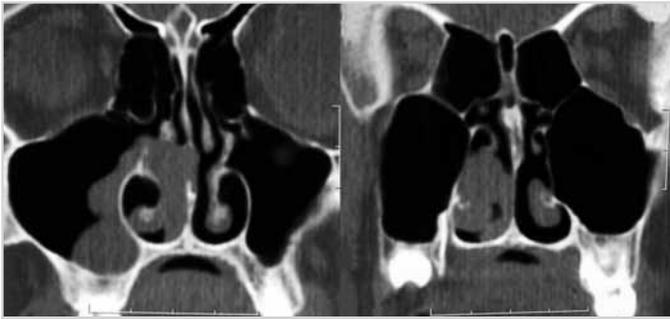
In coronal sections of paranasal sinus computed tomography, soft tissue density originating from the osteomeatal unit and extending into the maxillary sinus base, which is consistent with polyp, is seen
